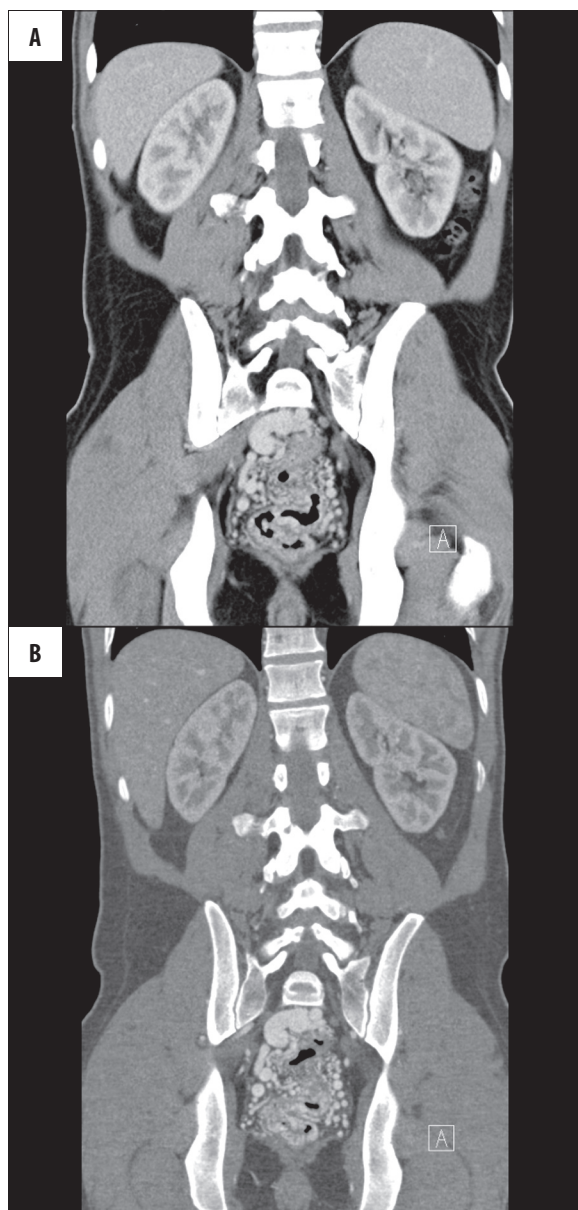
CT examinations, MPR reconstruction, frontal plane. The image of pelvic AVM in CT examination performed approximately two years later (B) shows no essential changes in comparison with the initial examination (A).
